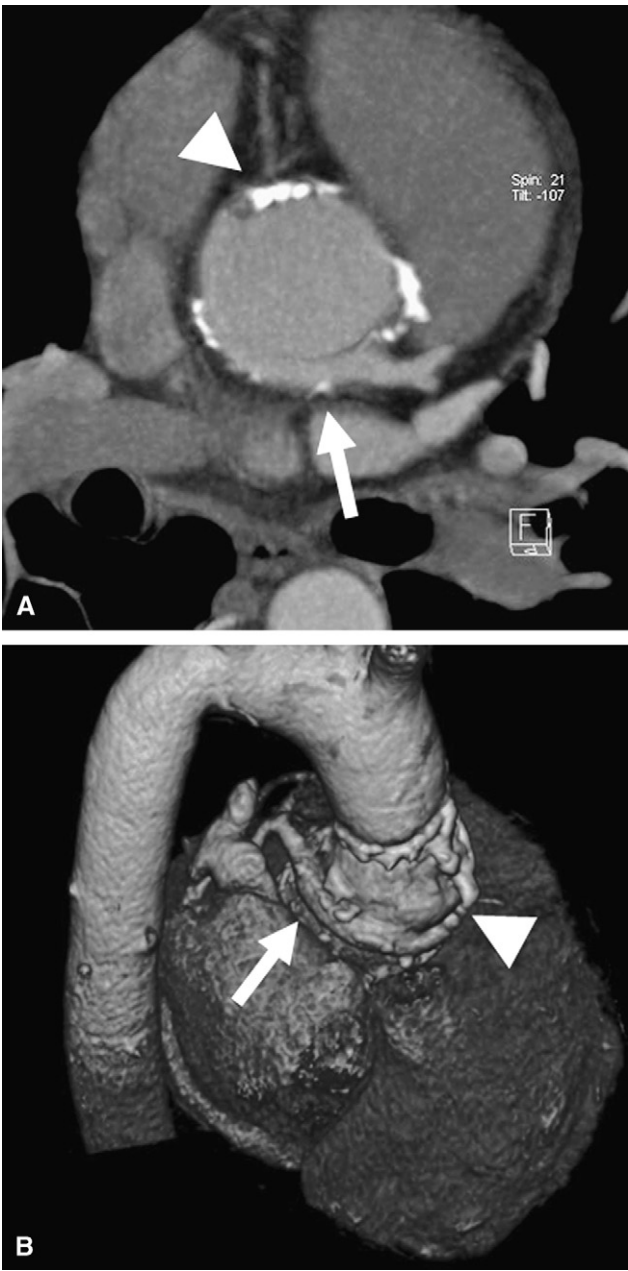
Dual-source computed tomographic angiogram in a 42-year-old man performed 7 years, 1 month after the Cabrol procedure. Transverse thin maximum-intensity projection (A) and volume-rendered images (B) demonstrate a patent Cabrol graft to the left main artery (arrows) and an occluded Cabrol graft to the right coronary artery (arrowheads).
